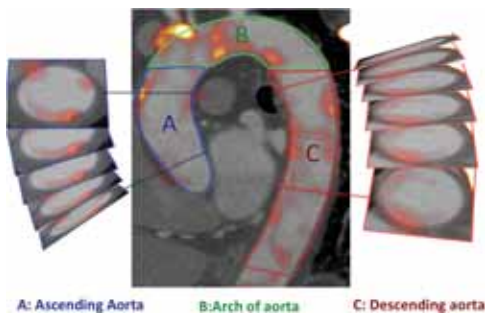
Measurement of 18F-fluorodeoxyglucose (18F-FDG) and 18F-fluoride (18F-fluoride) uptake in the aorta.
